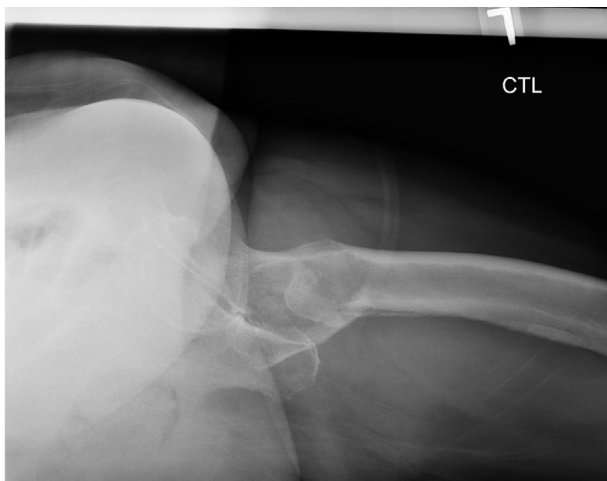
Lateral left hip radiograph.
